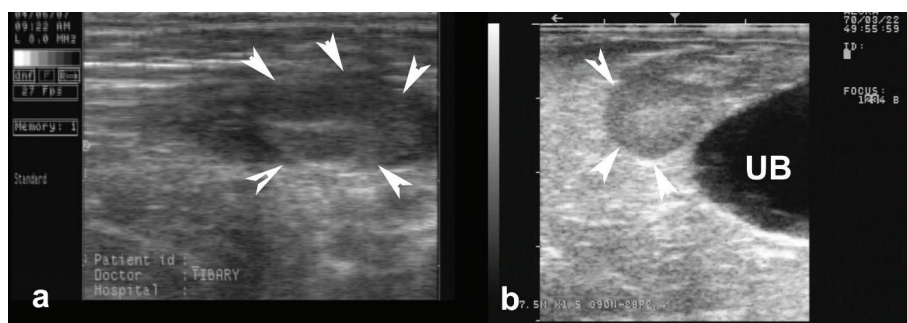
Transcutaneous ultrasonographic localization of the retained testis in a cryptorchid alpaca. Arrow indicated the retained testis, UB = urinary bladder.
